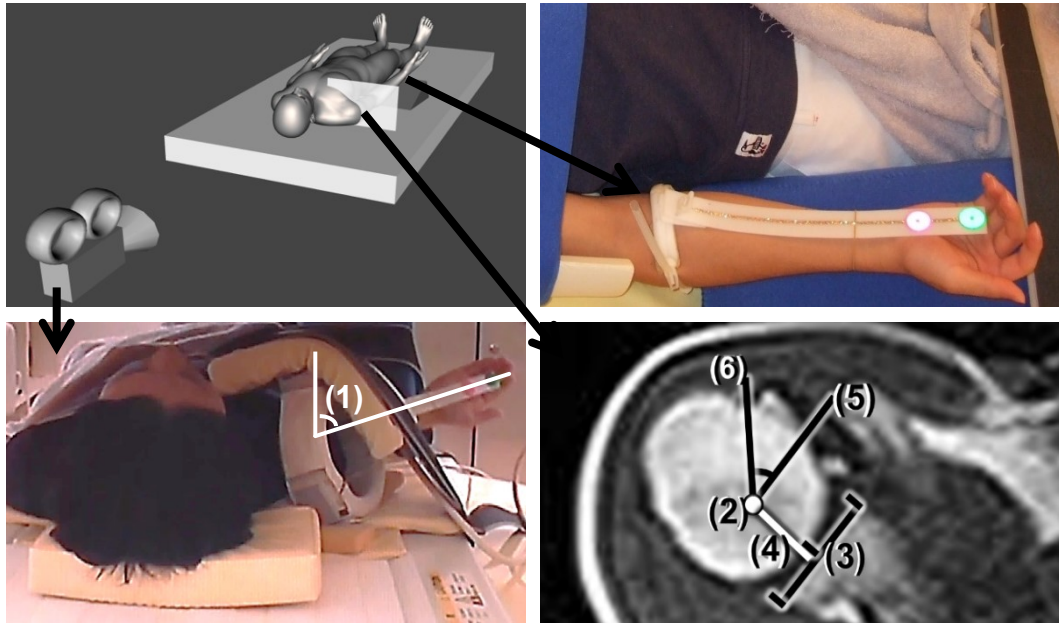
1 Experimental imaging. Fig. II-1a (left top) shows the view of the video camera that was synchronized with the MRI. Fig. II-1b (right top) shows a non-constraining brace applied to the subject's forearm. The position of the brace was not affected by pronation or supination of the forearm. Fig. II-1c (left bottom) is a frame captured by the video camera, showing (1) the shoulder rotation angle. Fig. II-1d (right bottom), taken from an MRI scan, shows how translation of the humeral head and rotation angle on MRI are defined. (2) Center of the humeral head. (3) Center of the glenoid fossa. (4) Line from the center of the humeral head perpendicular to the glenoid. Translation of the humeral head is defined as the distance between (3) and (4). (5) Line parallel to a line connecting the anterior and posterior edges of the glenoid and crossing the center of the humeral head. (6) Line connecting the bicipital groove to the center of the humeral head. The rotation angle of the humeral head is defined as the angle between (5) and (6).
